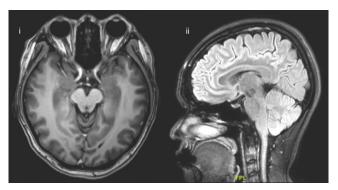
MRI of brain and orbit showing no abnormal signal intensity or focal enhancing lesion of the brain parenchyma; it also shows a normal-sized optic nerve with no bulging of the optic nerve head and no abnormal Gadolinium enhancement
